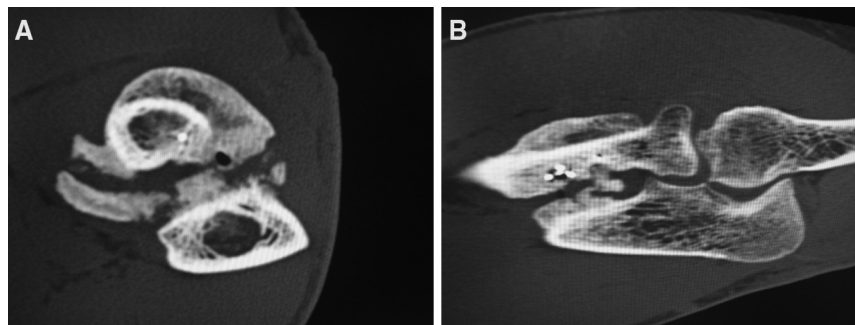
(A, B) Representative computed tomography images showing the location of heterotopic bone formation in a patient who previously had a biceps tendon repair.
